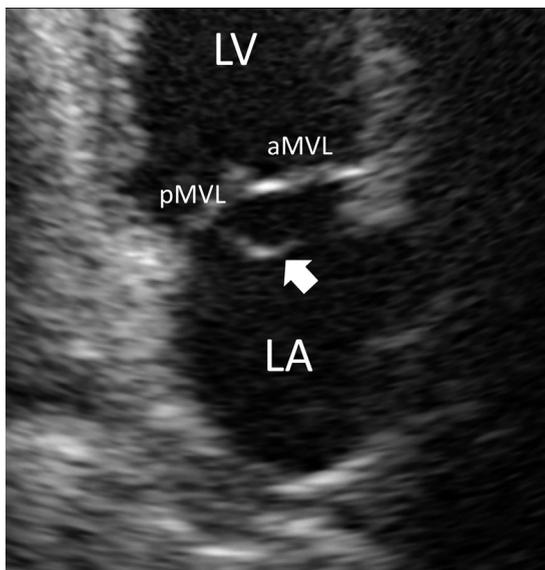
Transthoracic echocardiogram, apical two-chamber view. A flail posterior mitral valve leaflet is observed, with a thin and mobile structure in continuity with the leaflet (arrow) corresponding to a flail chordae tendineae. pMVL = posterior mitral valve leaflet. See Figure 1 legend for expansion of abbreviations.
